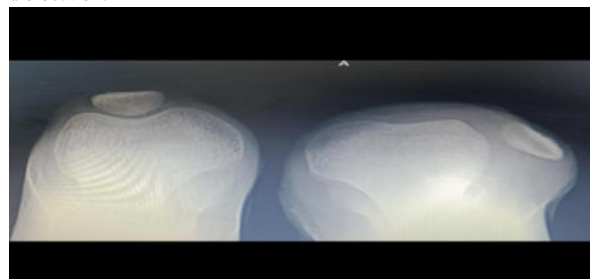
Skyline (Merchant) radiographic view showing lateral displacement of the left patella with a shallow trochlear groove, indicative of trochlear dysplasia associated with habitual patellar dislocation.
